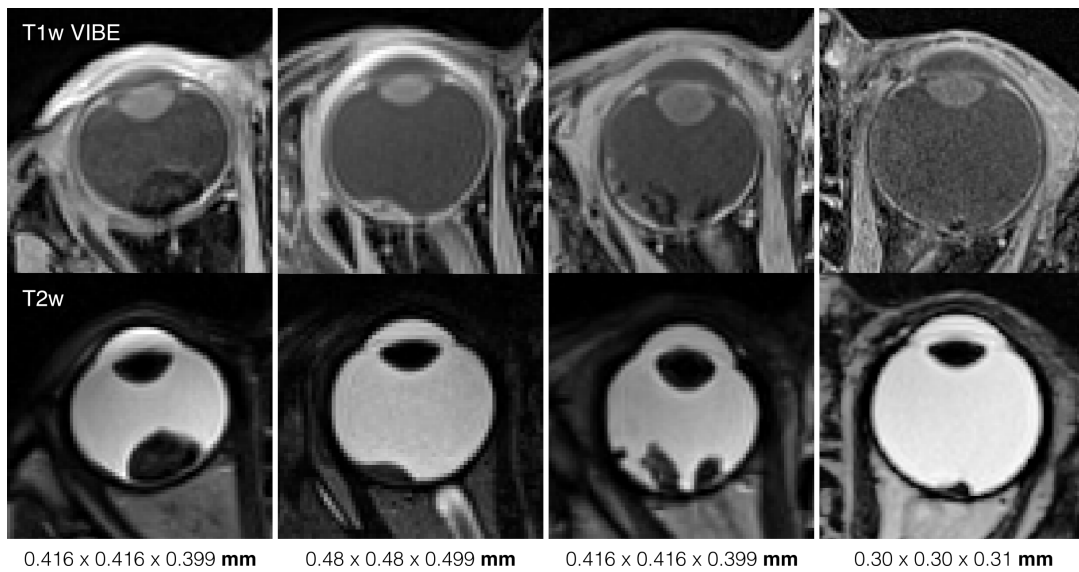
Retinoblastoma in MRI : Four examples of patients with retinoblastoma inside the eye cavity. The size of the tumor and the spreading pattern may vary depending on location and treatment.
